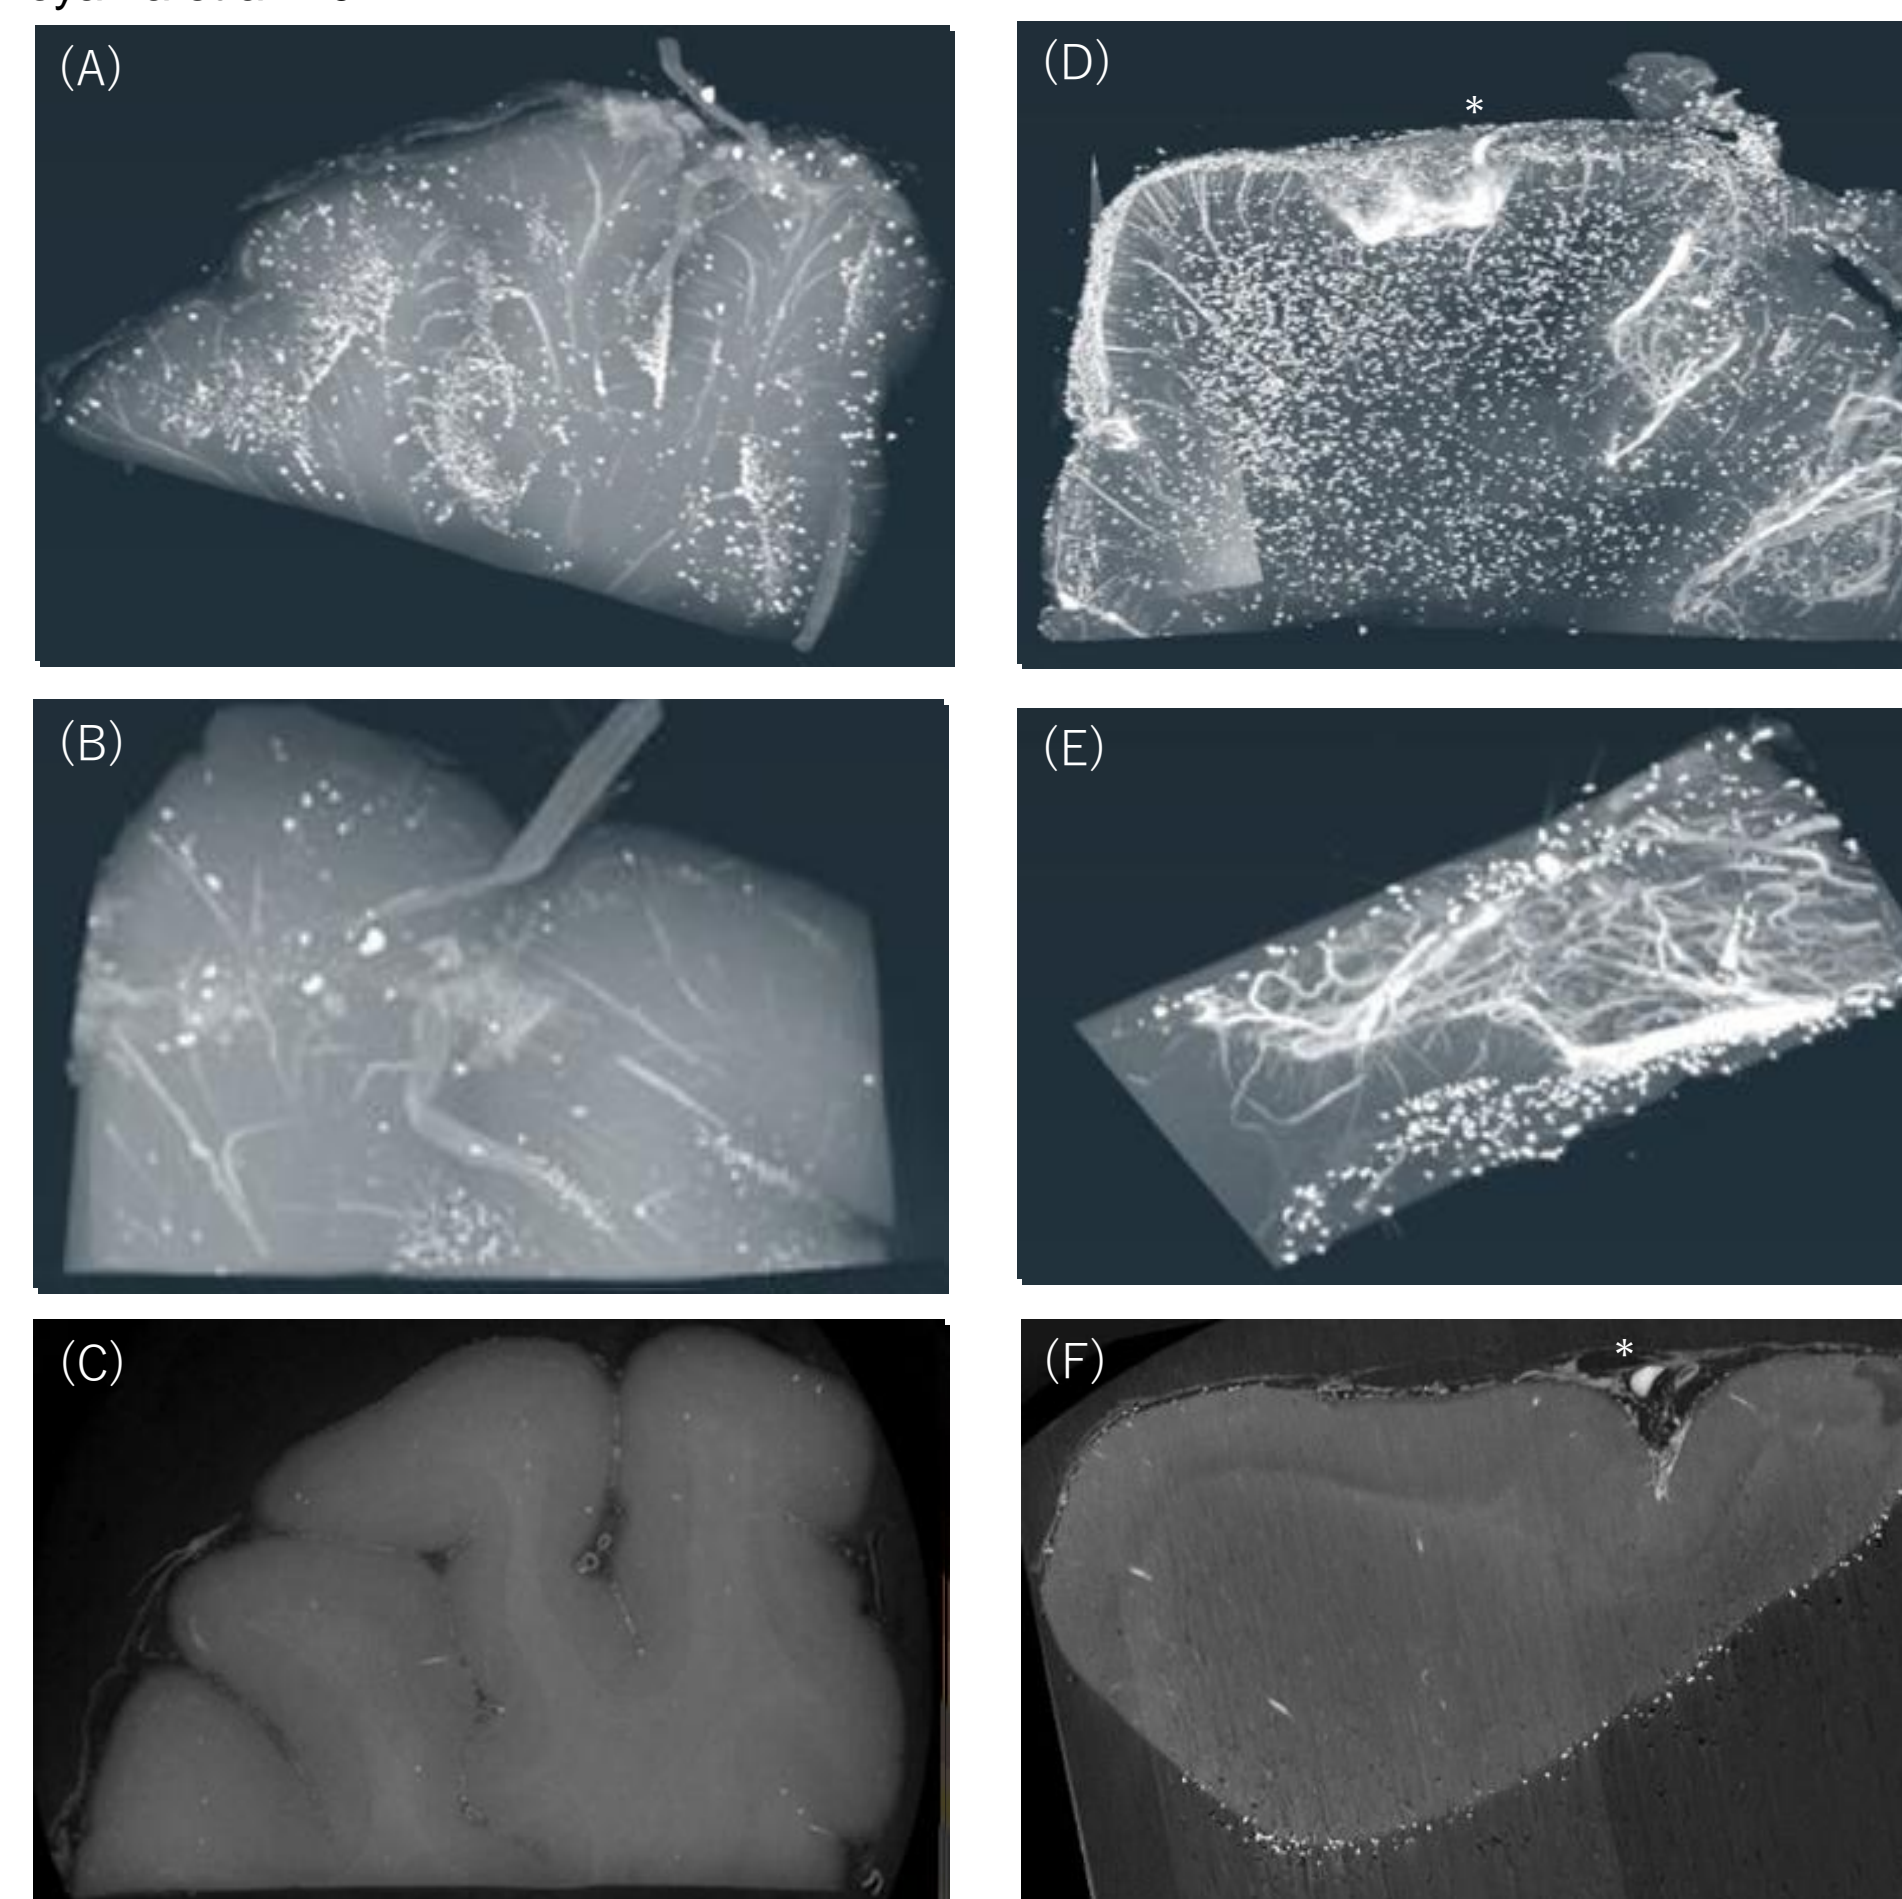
Phase reconstructed slices of Control (A, B, C) and CAA (D, E, F) brain sample obtained at higher resolution through X-ray phase contrast CT. The region of interest outlined in A is shown in B. White asterisk (\*) indicates the identical region of high CT value in 3D (D) and 2D (F) mode from CAA brain.
